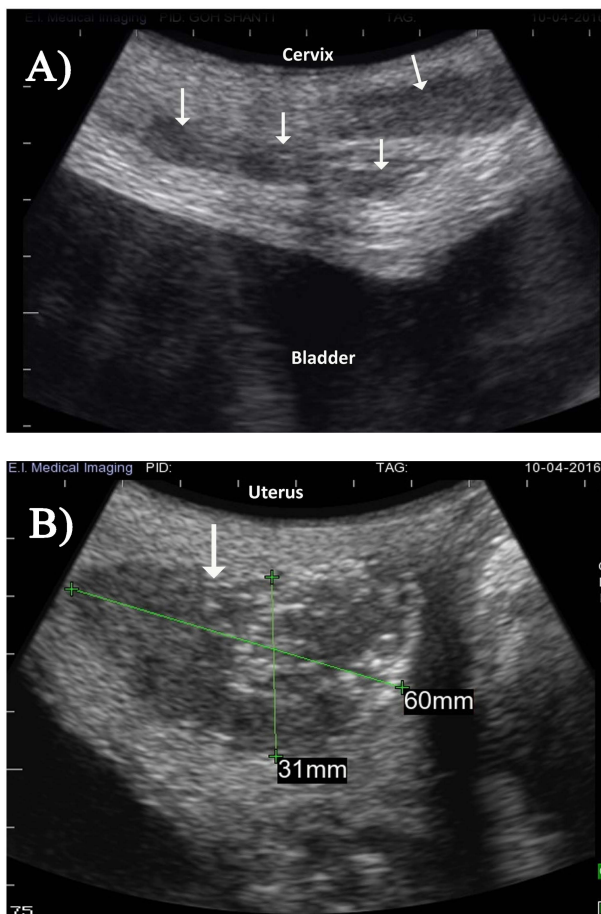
Ultrasonogram of cervix and uterus in a 31-year multiparous greater one-horned rhinoceros (GOHR). Note: multiple A) cervical and B) uterine leiomyomas (arrows).
